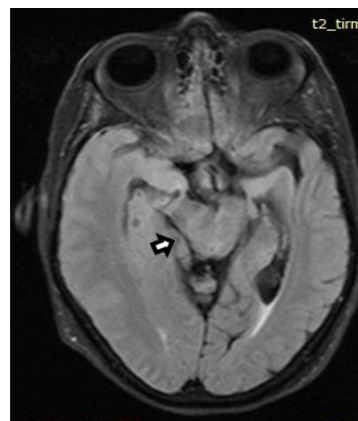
MRI image of temporal herniation: the medial part of the temporal lobe compresses the brainstem
